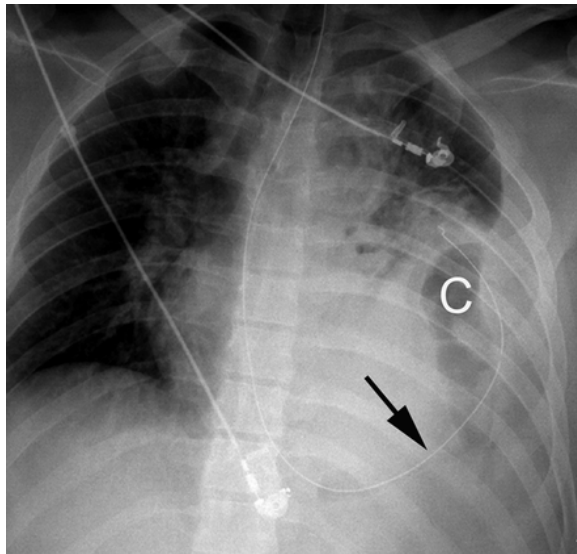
Chest radiograph shows a gas-filled viscus above the left hemidiaphragm that corresponds to the colon (C). A nasogastric tube is clearly seen in the thoracic cavity (arrow).
